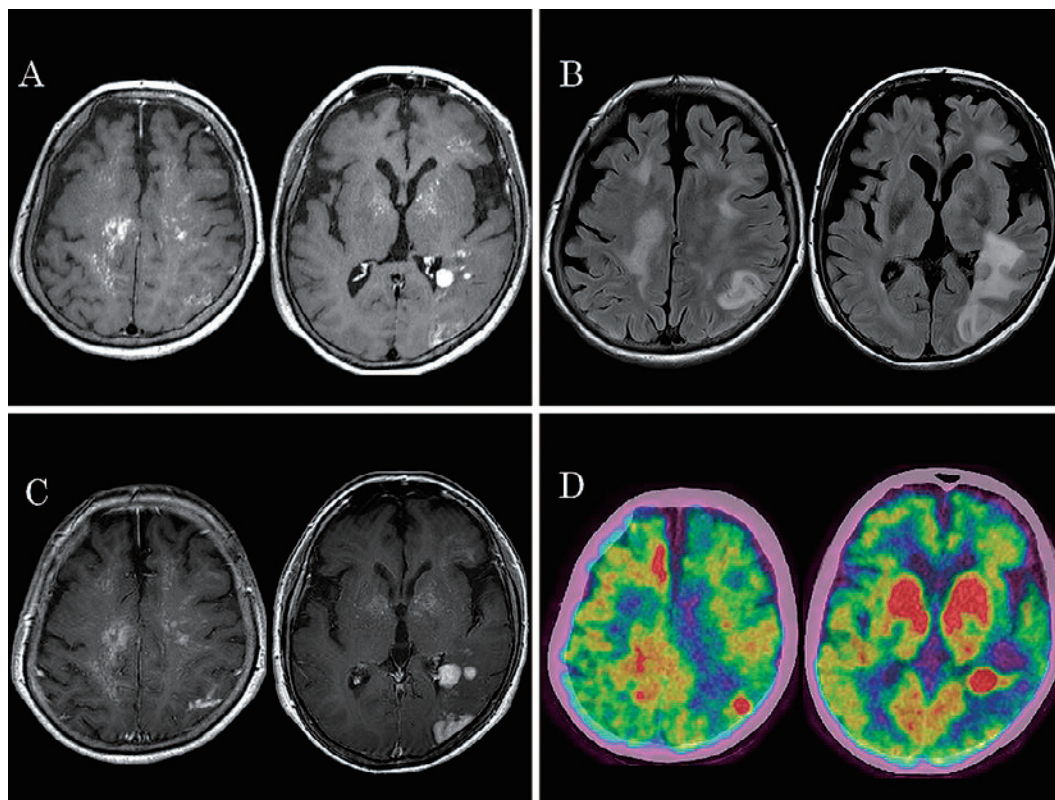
Brain MRI upon admission and after MTX withdrawal and FDG-PET findings after MTX withdrawal. A: Gd-T1WI upon admission showing multiple lesions in the bilateral cerebral hemisphere and basal ganglia. B: FLAIR images upon admission showing hyperintensity surrounding lesions. C: Gd-T1WI after MTX withdrawal showing no regression. D: FDG-PET after MTX withdrawal showing increased FDG uptake in the lesion.
